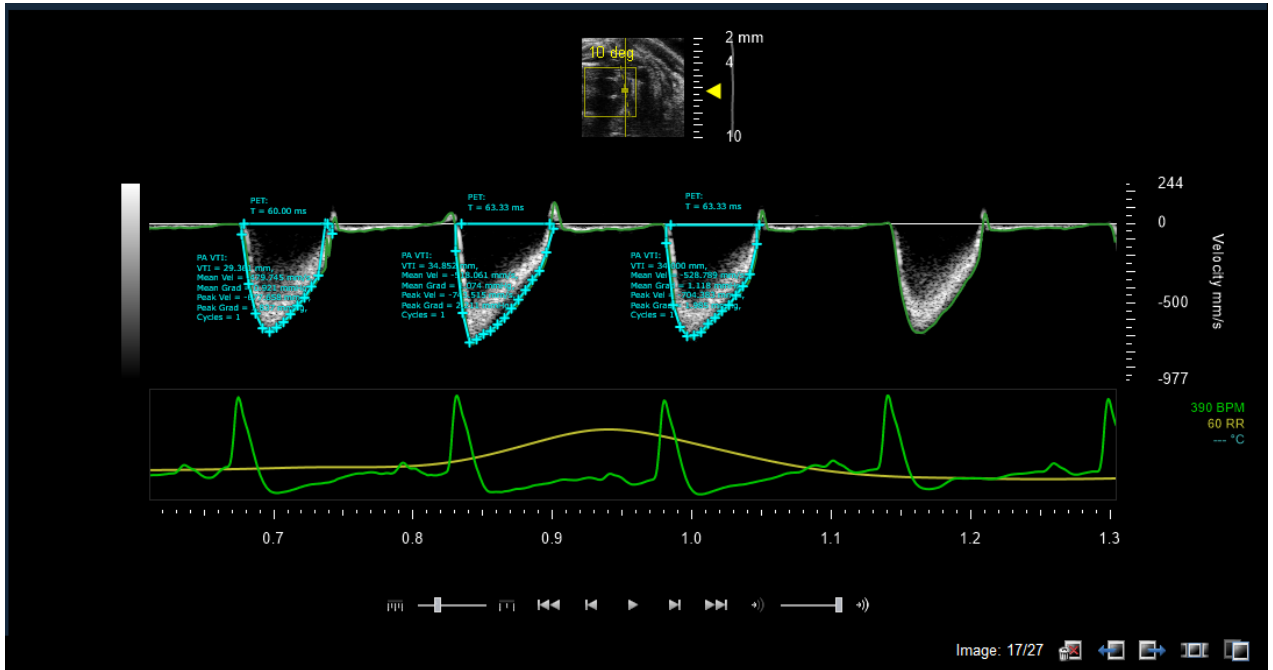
Parasternal short-axis view, at aortic valve level with pulse wave Doppler (PW) of the pulmonary valve.
